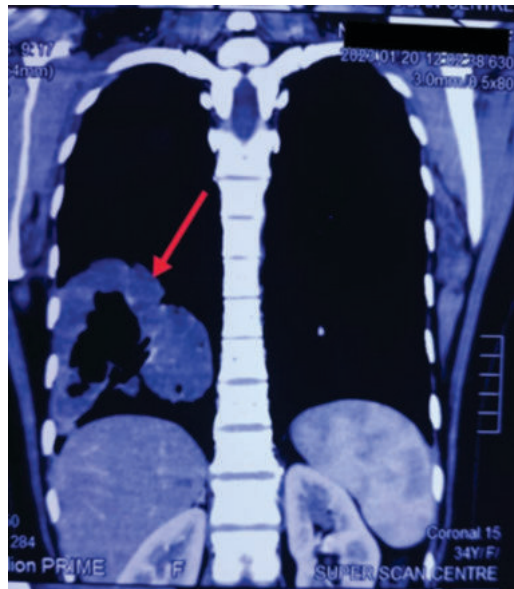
CT Scan Showing Right Lower Lobe Mass With Central Leucencies.
